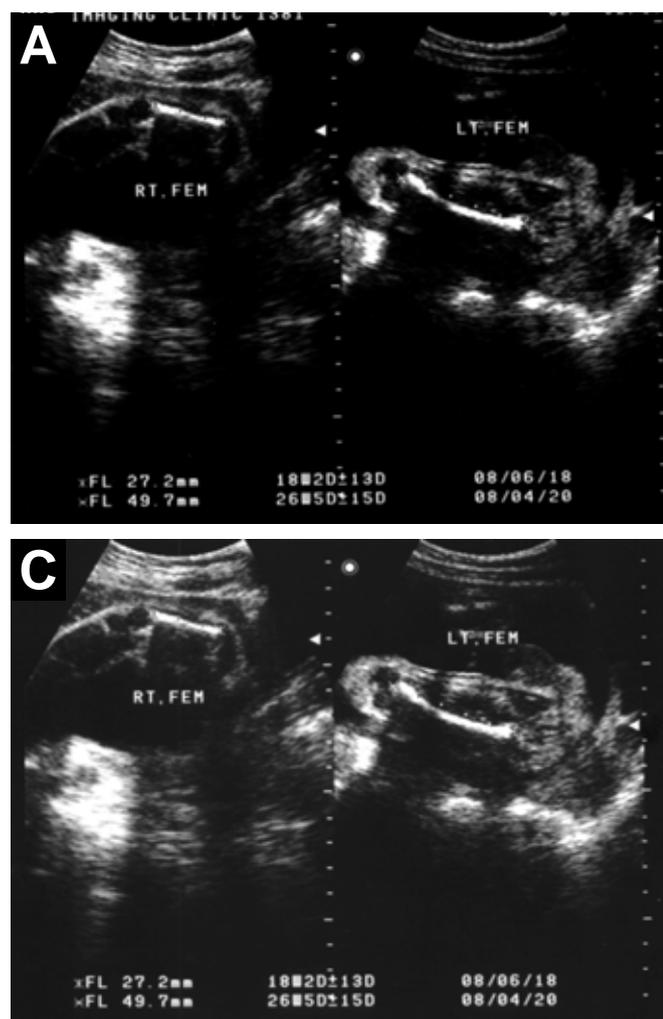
Trans-abdominal two-dimensional ultrasonography of the fetus.
